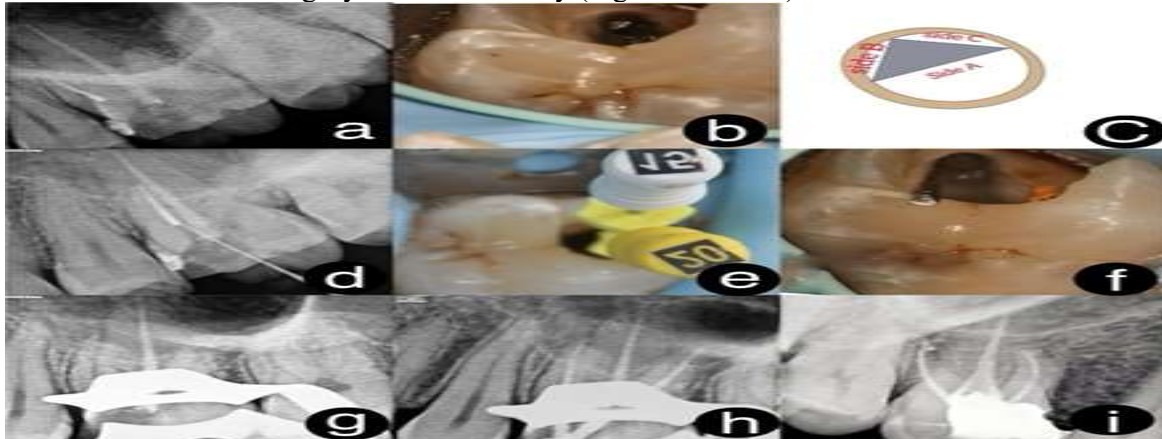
a) Pre operative radiograph b) Creating straight line access c) Pictorial representation of Mesiobuccal canal
